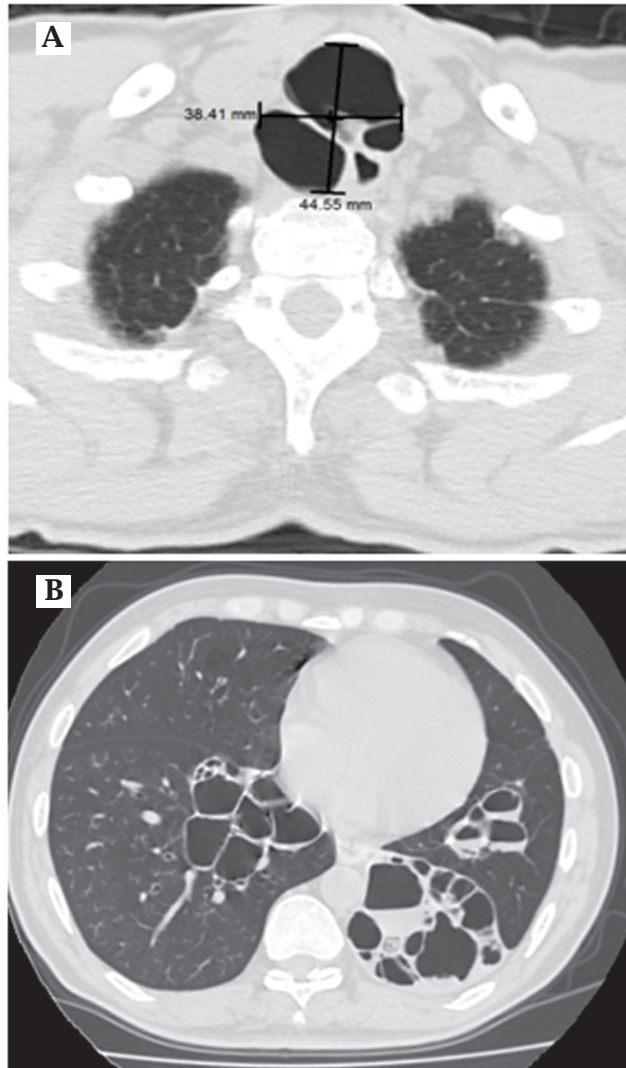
High resolution computed tomography (HRCT) of chest showing (A) coronal diameter of 38.4 mm and sagittal diameter of 44.5 mm of the trachea with multiple tracheal diverticulas, and (B) bilateral bronchiectasis.
